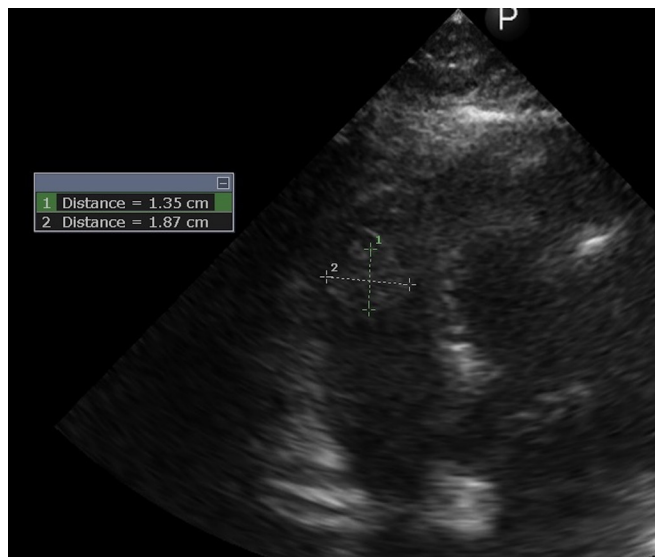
Pre-tissue plasminogen activator: bedside point-of-care ultrasound showing a mass of echoes measuring 19×14 mm in the right ventricular cavity most consistent with thrombus.
